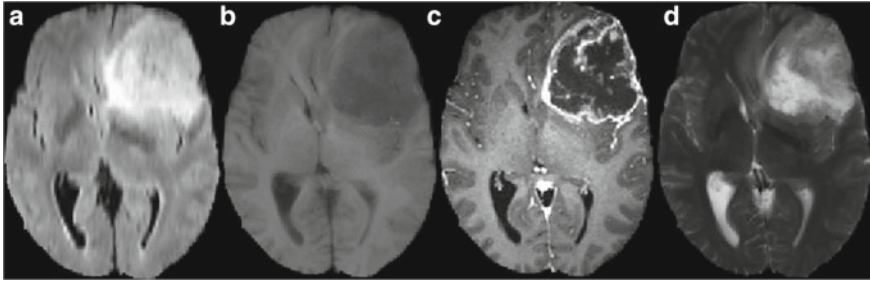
Row-1 show MRI images (FLAIR). a T₁-weighted. b Post-contrast T₁-weighted. c T₂-weighted. d Brain with tumor [8–10]
